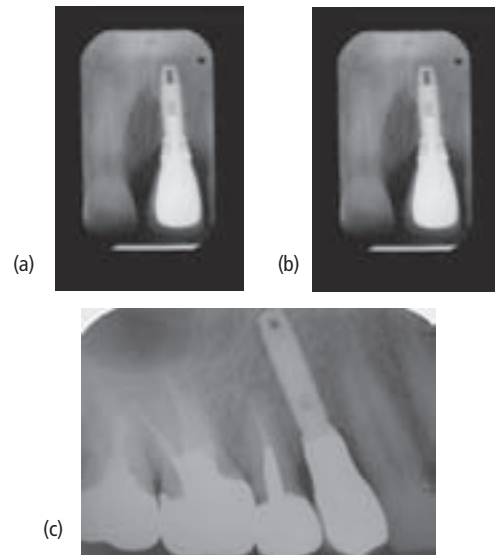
(a) Periapical radiograph made after cementation of metal ceramic crown. (b) Periapical radiograph of an implant that was placed about 3 mm apical to the cemento-enamel junction of adjacent teeth. The distance from the incisal edge to the top of the implant can become fairly substantial, permitting greater forces to be applied to the metal components. (c) An implant was placed into a severely resorbed maxillary first premolar site. The distance from the implant to the occlusal surface is almost equal to the length of the implant.
